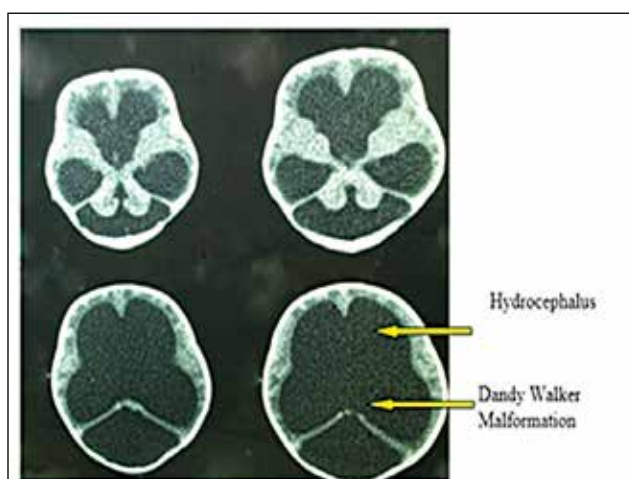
CT scan of brain showing Dandy Walker Malformation with hydrocephalus
